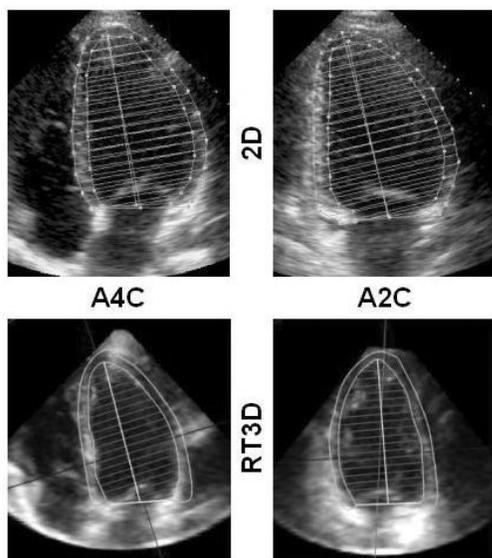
Top: End-diastolic apical 4- and 2-chamber views of the left ventricle obtained in a patient using conventional 2D imaging. Bottom: End-diastolic, anatomically correct apical views selected off-line from a RT3D dataset obtained in the same subject. Manually traced endocardial and epicardial boundaries were used to calculate LV mass (see text for details).
